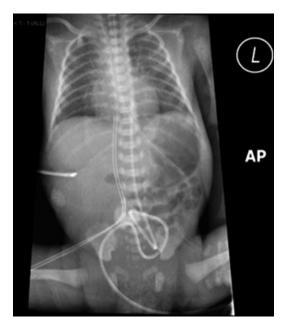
Plain chest and abdomen radiograph in a neonate demonstrating the appropriate position of the arterial and venous umbilical catheters. The left-sided arterial umbilical catheter (UAC) courses caudal to its junction with the internal iliac artery following which it travels cephalad through the iliac system and the aorta. The right-sided umbilical venous catheter (UVC) travels cephalad from the umbilical vein through the ductus venosus into the inferior cavo-atrial junction (Image courtesy of Dr. Gurdeep Mann, Sidra Medical and Research Center, Qatar)
